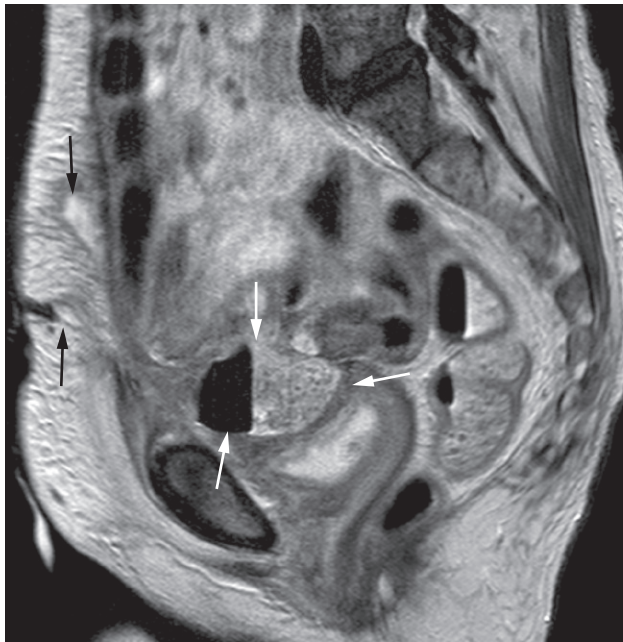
T2-weighted MRI scan in the sagittal plane demonstrating a pelvic abscess (white arrows) containing faecal material and air, which has formed a fistula with the anterior abdominal wall (black arrows).
